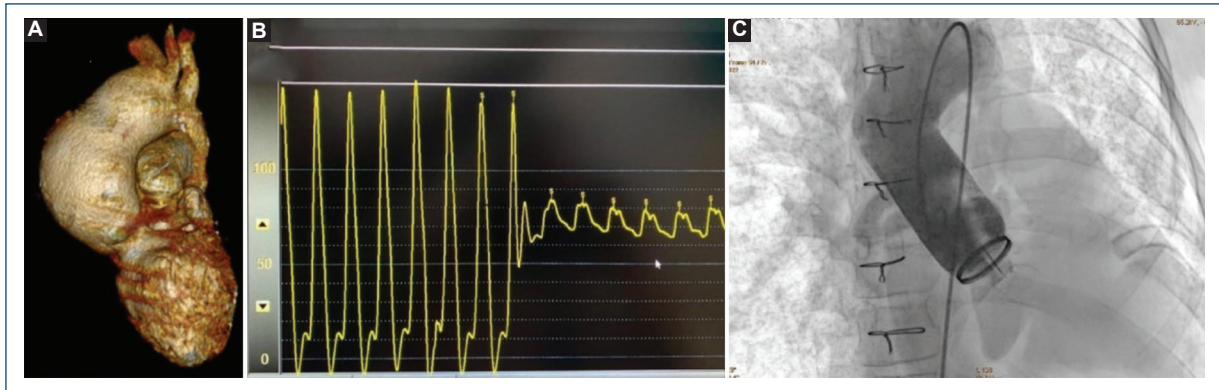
A: cardiac computed tomography 3D volume-rendering reconstruction shows aneurysmal dilatation of aortic root and ascending aorta. B: pullback tracing from left ventricle to aorta. C: valved conduit angiography shows a lack of opening of one disc in systole.
